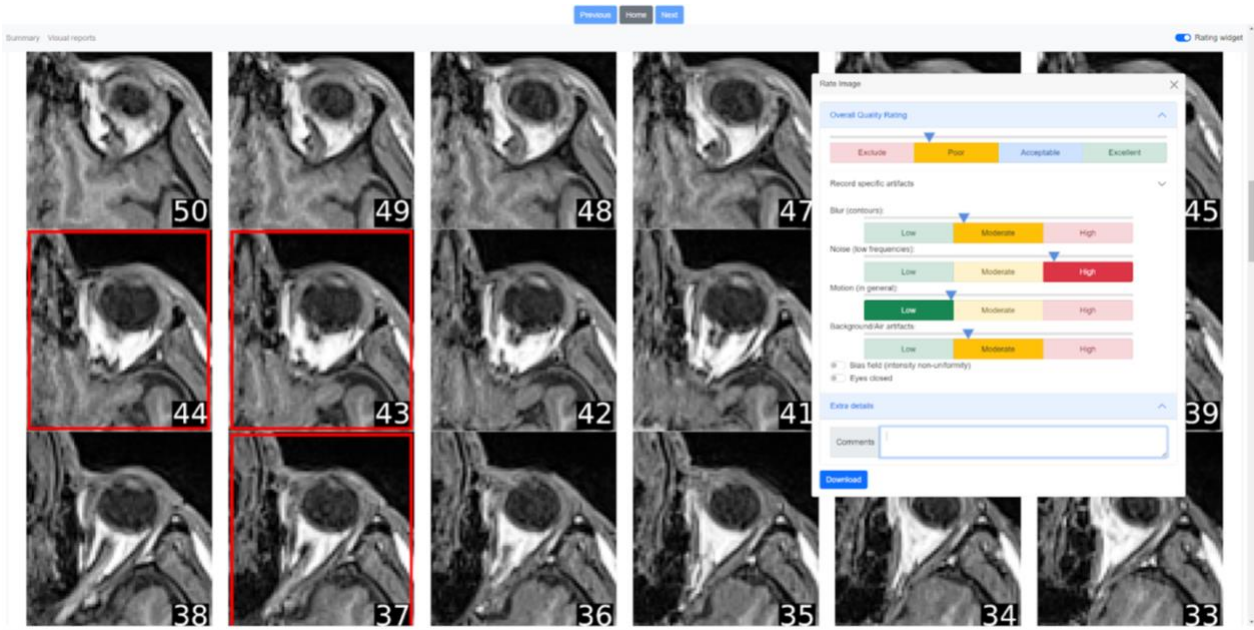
Example of MR-Eye QC report with rating widget. To assess the quality of the eyes of the MR images, we created an html-based report for each of them: a series of axial slices centered and cropped on the right eye. The rating widget on the right is composed of several sliders regarding overall quality [0-4], blur, noise, motion, and background artifacts. Also, it includes two toggle buttons for bias field and eyes closed/open and a text box for further comments. Additionally, it's possible to select specific slices where heavy artifacts are present (red squares will appear).
